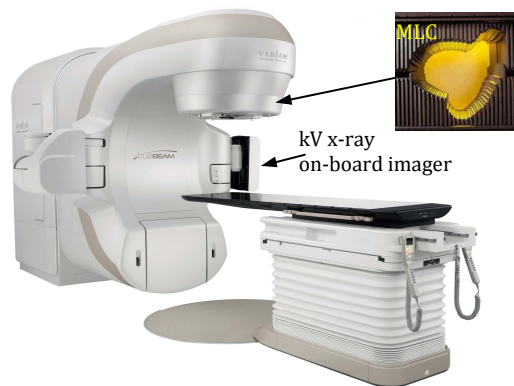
A modern medical linear accelerator or linac (Truebeam, Varian Medical Systems, Palo Alto). The linac is equipped with a 120-leaf multileaf collimator (MLC) to shape each radiation field and an orthogonally-mounted kV x-ray on-board imager (OBI) for patient positioning and monitoring.
